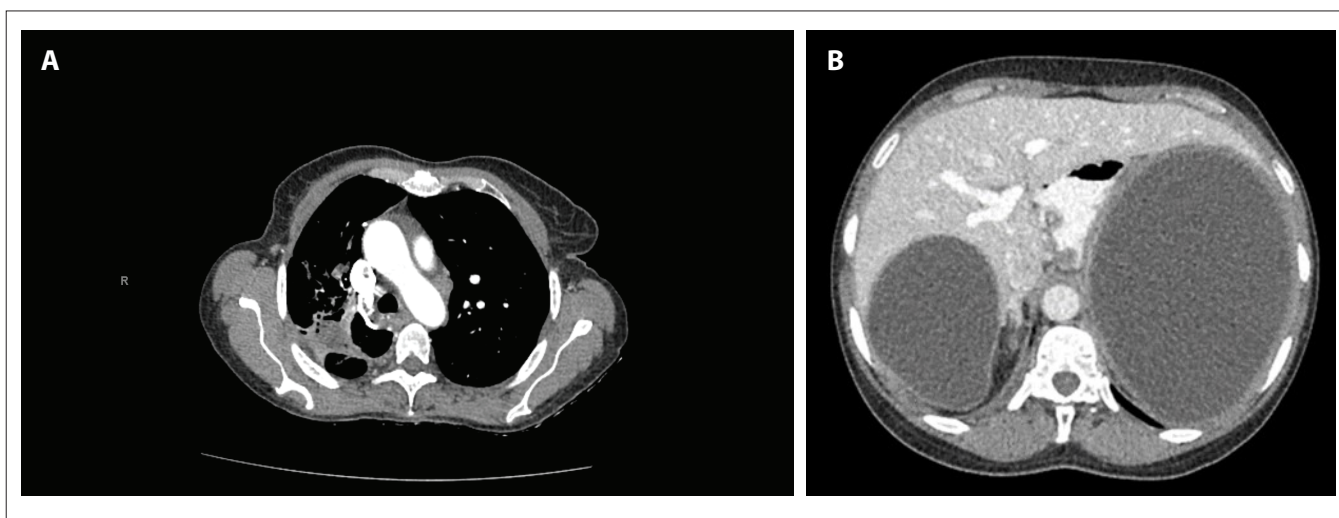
(A) Computed tomography scan of the chest, showing multiple low-density material with gas locules in the right upper-lobe cavities, in keeping with aspergillomas. (B) Computed tomography scan of the abdomen, showing large cysts in the liver and spleen.
